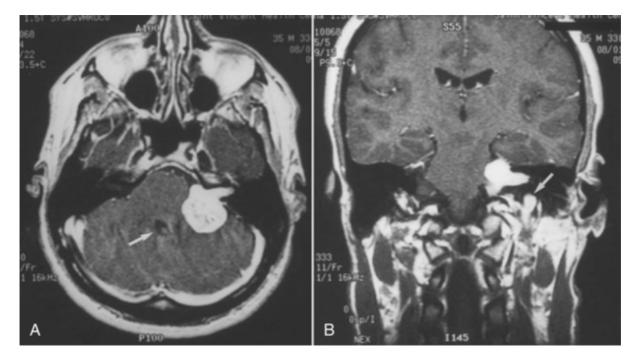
T1-weighted contrast–enhanced magnetic resonance imaging scan of a left acoustic neuroma. A, Axial image showing a 3-cm tumor with compression of the brain stem. The fourth ventricle is patent *(arrow)*. B, Coronal image demonstrating the inferior extent of the tumor. Note the relationship to the jugular fossa *(arrow)*.
